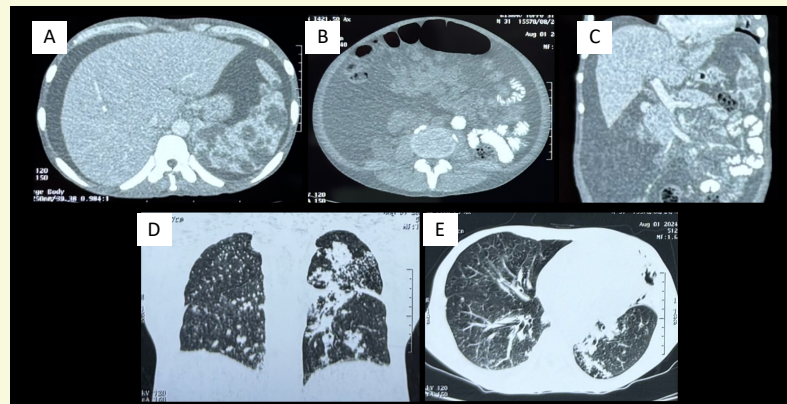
CECT-W/A (A,B : Axial & C : Coronal) showing ascites, splenic hypodense lesions & multiple enlarged, confluent abdominal lymph nodes with loss of fatty hilum s/o Lymphoma; HRCT-Thorax (D & E) with lesions s/o Tubercular infection
